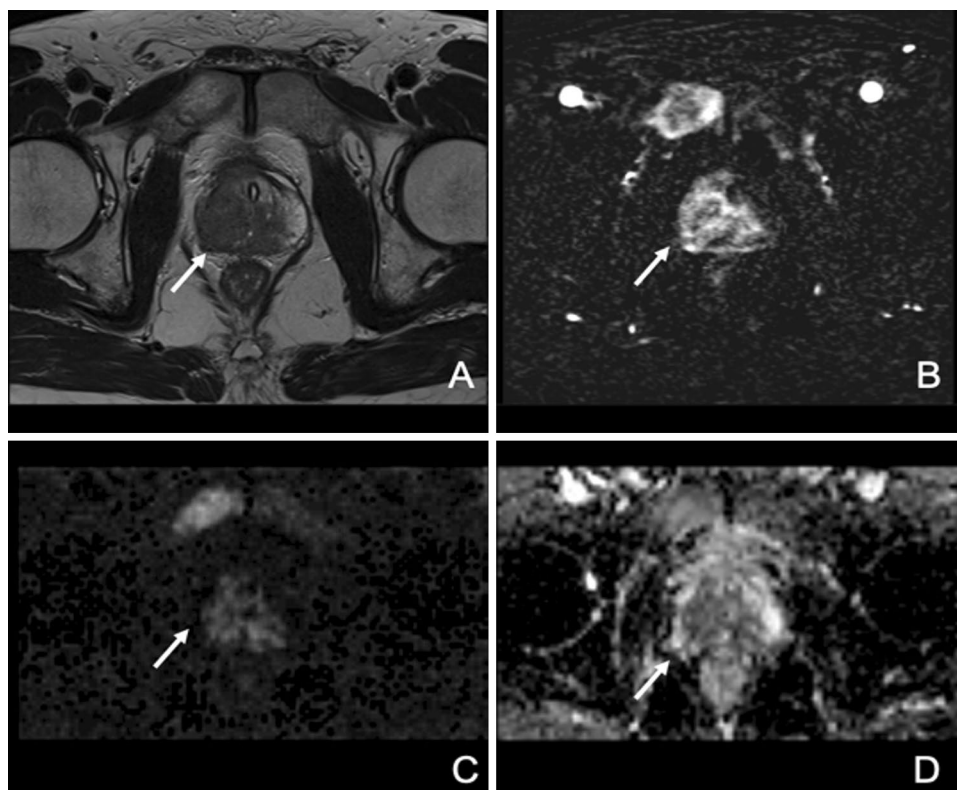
Alteration of the intermediate right PZ and TZ scored as a PI-RADS 5: A axial view of T2W showing a low signal alteration in the PZ and TZ (white arrow); B axial view of DCE on 3D T1W GRE image evidencing an early enhancement in correspondence of the alteration in the PZ and TZ (white arrow); C axial view of DWI (b 1500) showing a hyperintense alteration in the PZ and TZ (white arrow); D axial view of ADC map showing a hypointense alteration in the PZ and TZ (white arrow)
